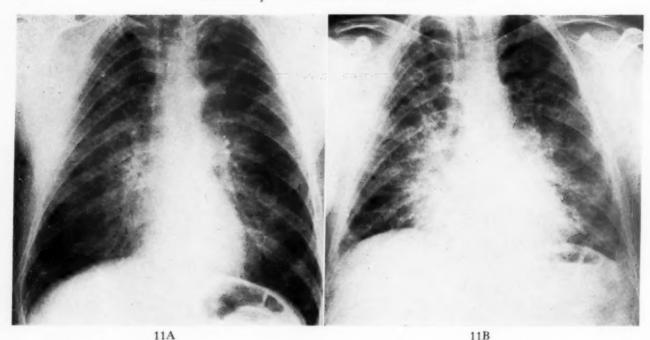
Case II. A, roentgenogram of the chest taken on August 23, 1954, showing a diffuse interstitial infiltration throughout both pulmonary fields. B, roentgenogram taken on November 3, 1954, showing a perihilar infiltration with increase in radial markings throughout both lungs. The infiltration follows the course of the bronchi into the upper lobes. Patchy pneumonic consolidations are present in the bases.
